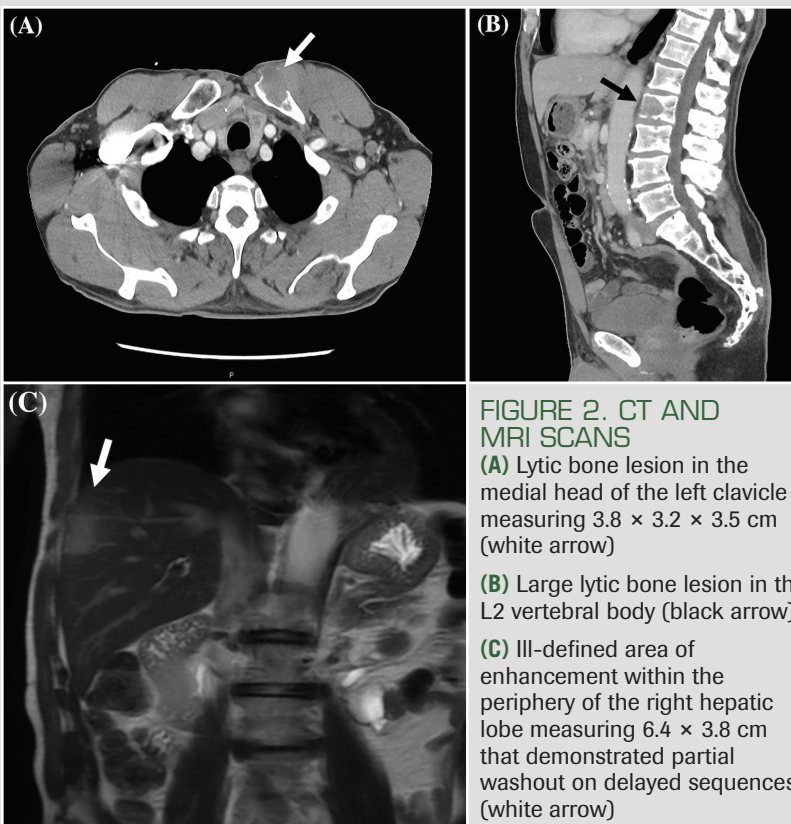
CT AND MRI SCANS
